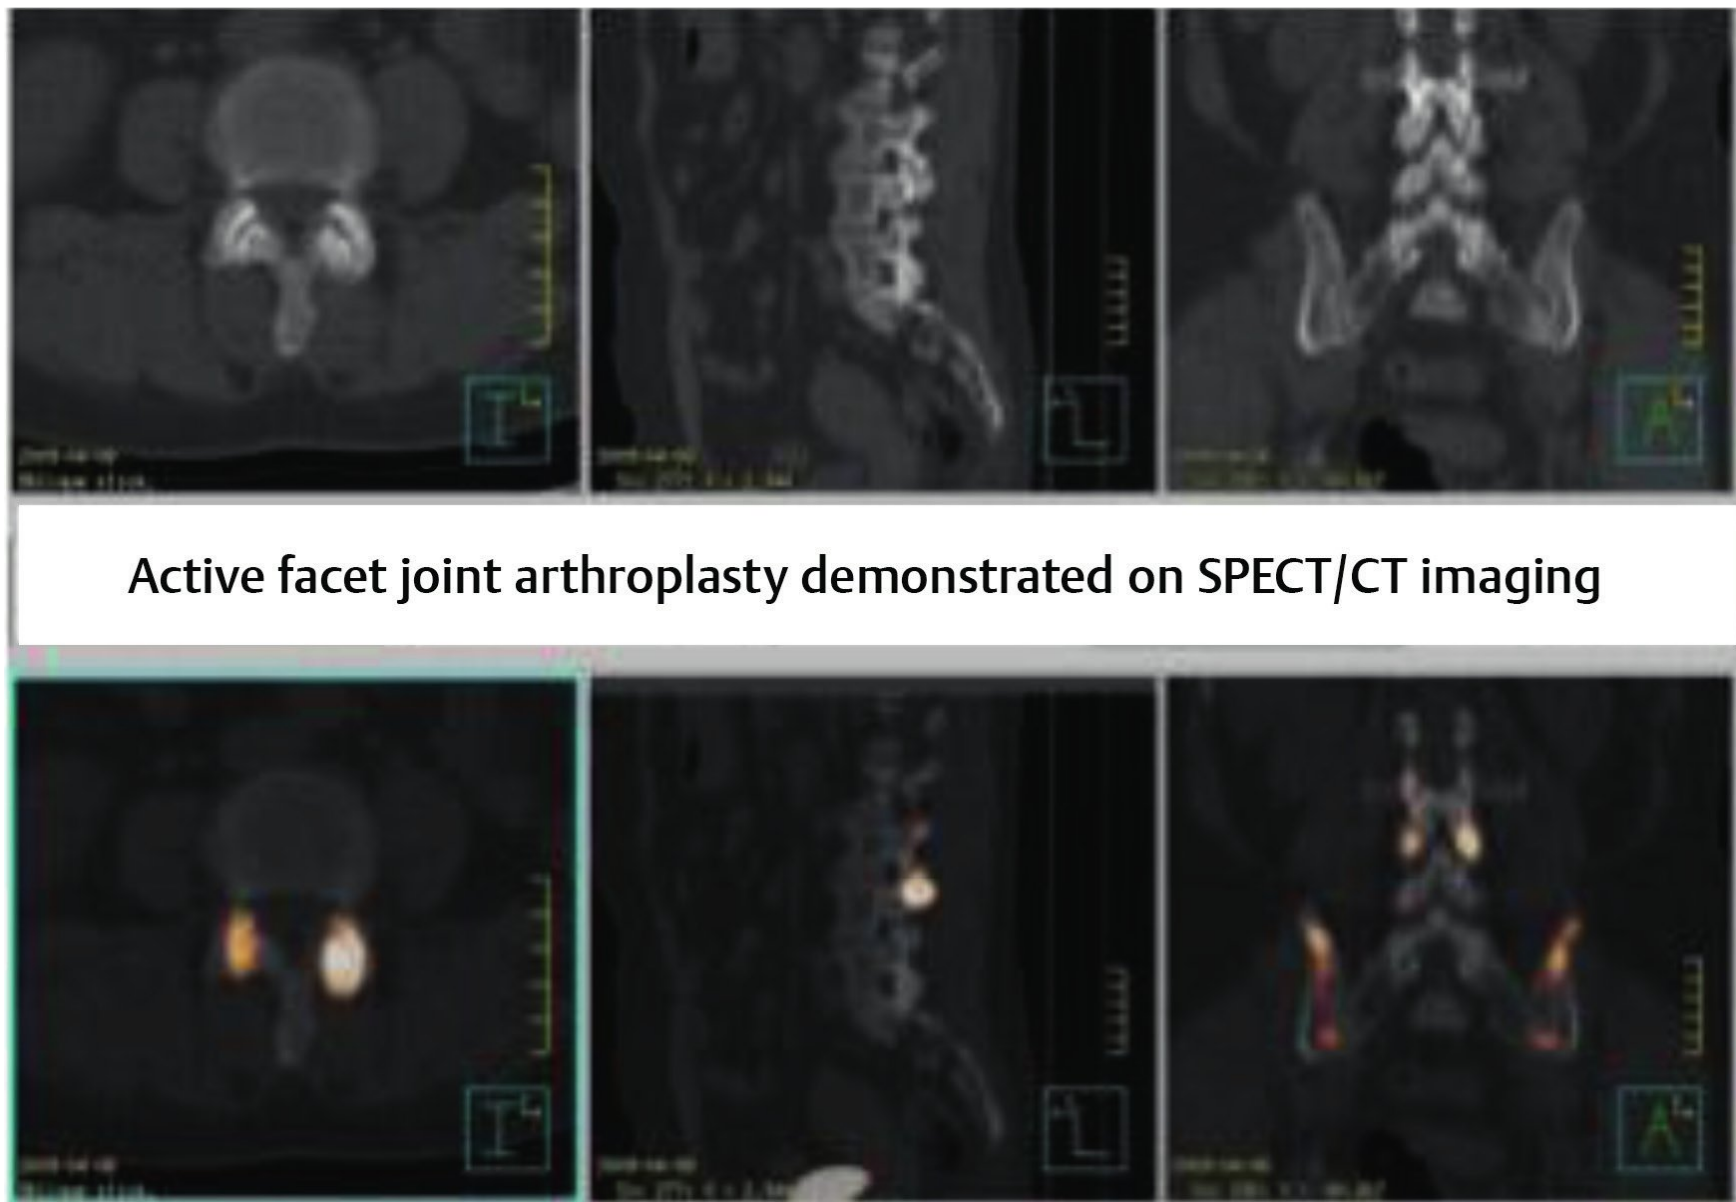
Single-photon emission computed tomography (SPECT/CT).
